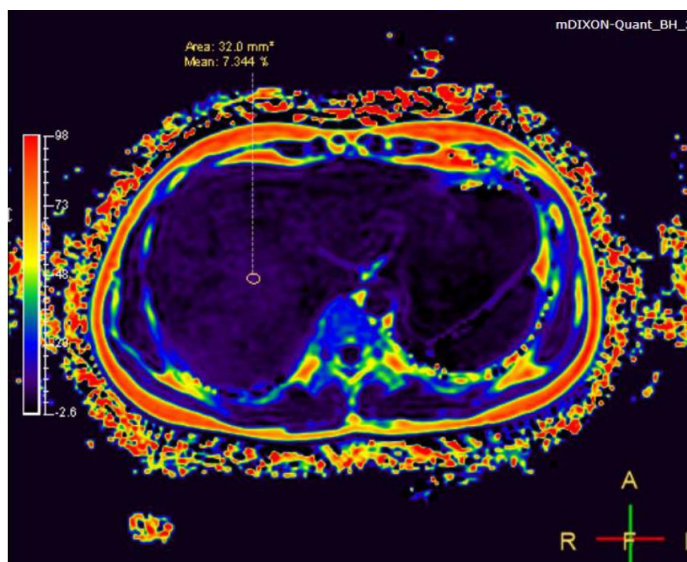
MRI-PDFF of this candidate was 7.3%
